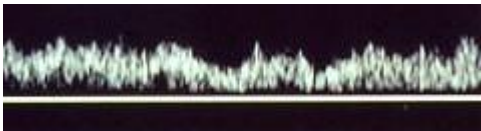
The Doppler spectral waveform pattern from the portal veins normally exhibits low velocity, quasi-steady flow. Portal venous velocity normally increases postprandially and varies with respiration and alterations in cardiac flow.
